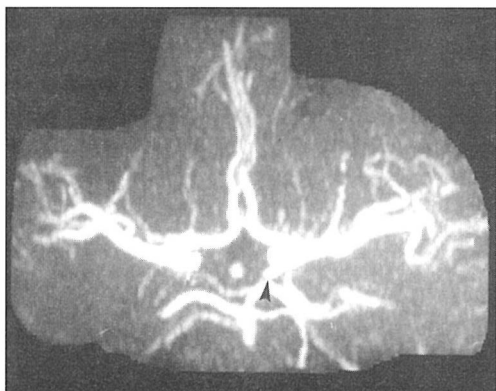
On CTA images an infundibular widening of the posterior communicating artery (arrow) was misinterpreted as an aneurysm.
